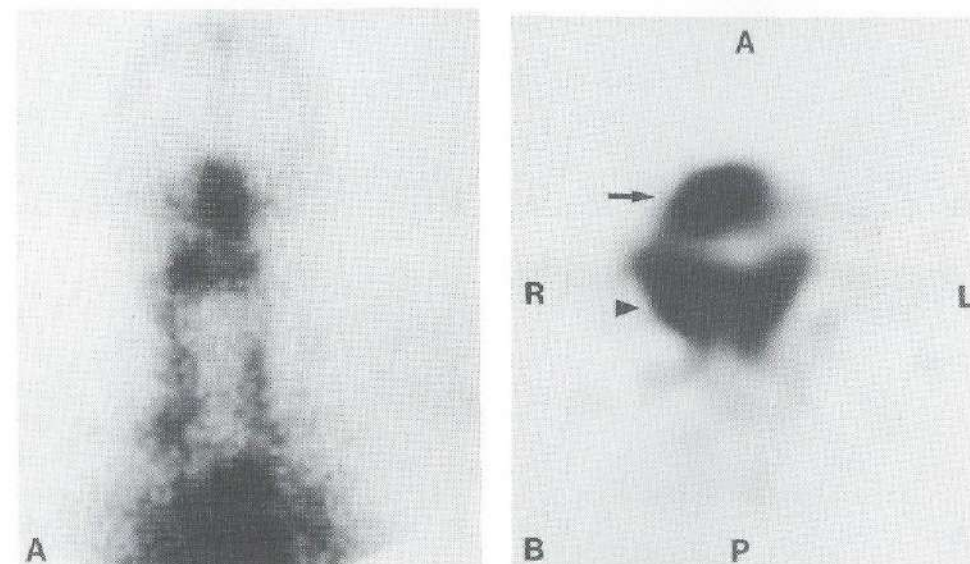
(A) Patient 32. Planar anterior image of the head and neck 21 h after injection of <sup>99m</sup>Tc-labeled E48 IgG. Increased activity is seen in the mouth region on the right. Only one spot can be distinguished. (B) Axial SPECT image of the same patient shows two separate spots representing the primary tumor in the anterior floor of mouth (arrow) and the subdigastic lymph node metastases (arrowhead) on the right. A=anterior; P=posterior; L=left; R=right.
